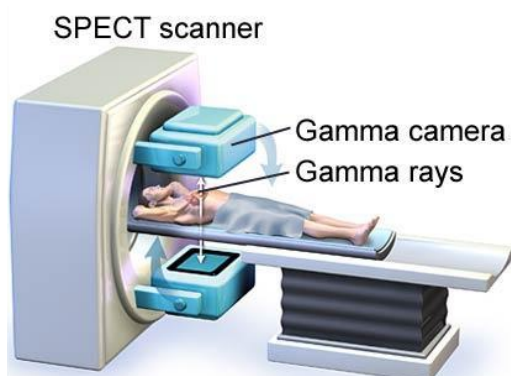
SPECT machine and parts.
